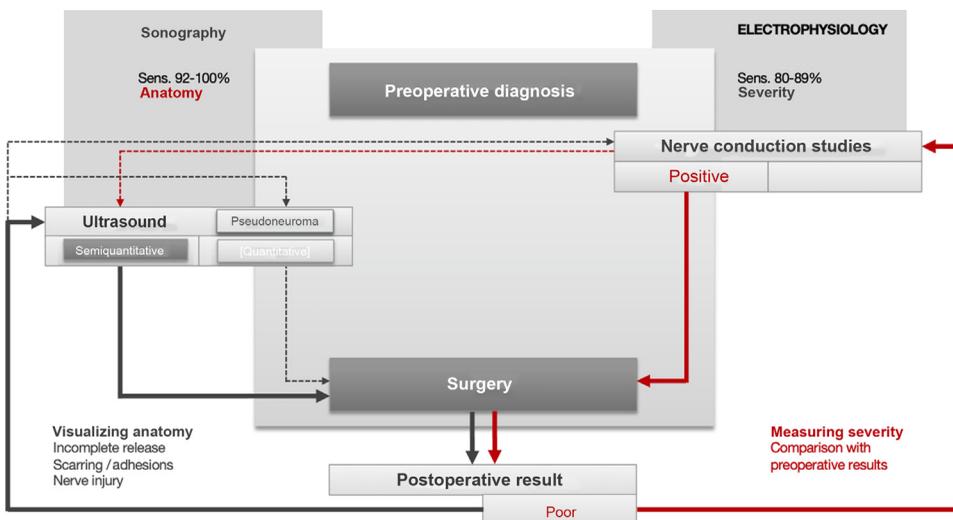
Comparison between sonography and electrophysiology—postoperative workflow. The value of postoperative ultrasound lies in the visualization of the anatomy. While preoperative ultrasound diagnostics focus on the CSA of the median nerve, in the postoperative setting mainly semiquantitative sonographic parameters such as mobility and scarring are of interest. NCS, on the other side, provide a direct comparison of preoperative and postoperative nerve function if preoperative baseline values have been obtained. Depending on the specific postoperative situation, both diagnostic modalities have their specific indications and can complement each other.
